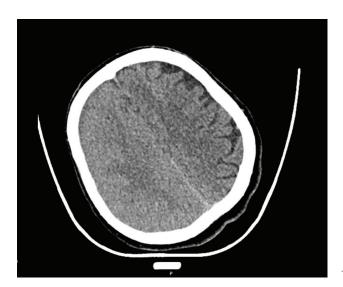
CT without contrast media.
